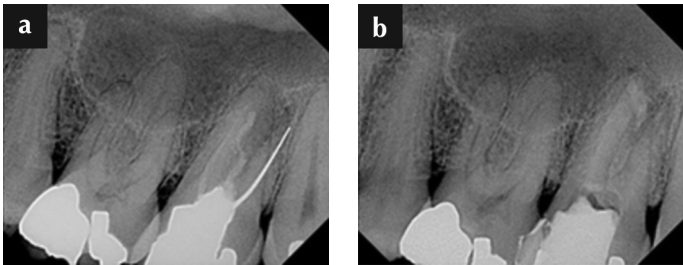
Tooth No. 15 preoperative radiograph.
